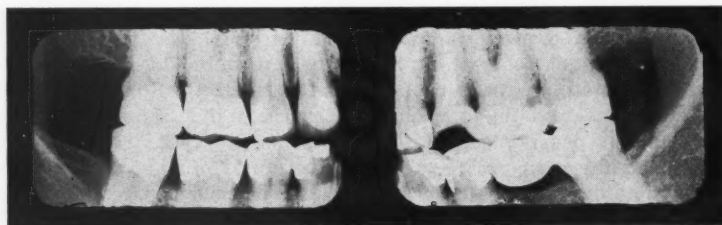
Bite wing roentgenograms. Technical factors: Distance: 11 inches. Milliampères: 10. Time of exposure: 10 seconds. K. V. P.: 55. Time of development: 7 minutes. Owing to lowering of K. V. P., it is necessary to increase exposure time for bite wings.
